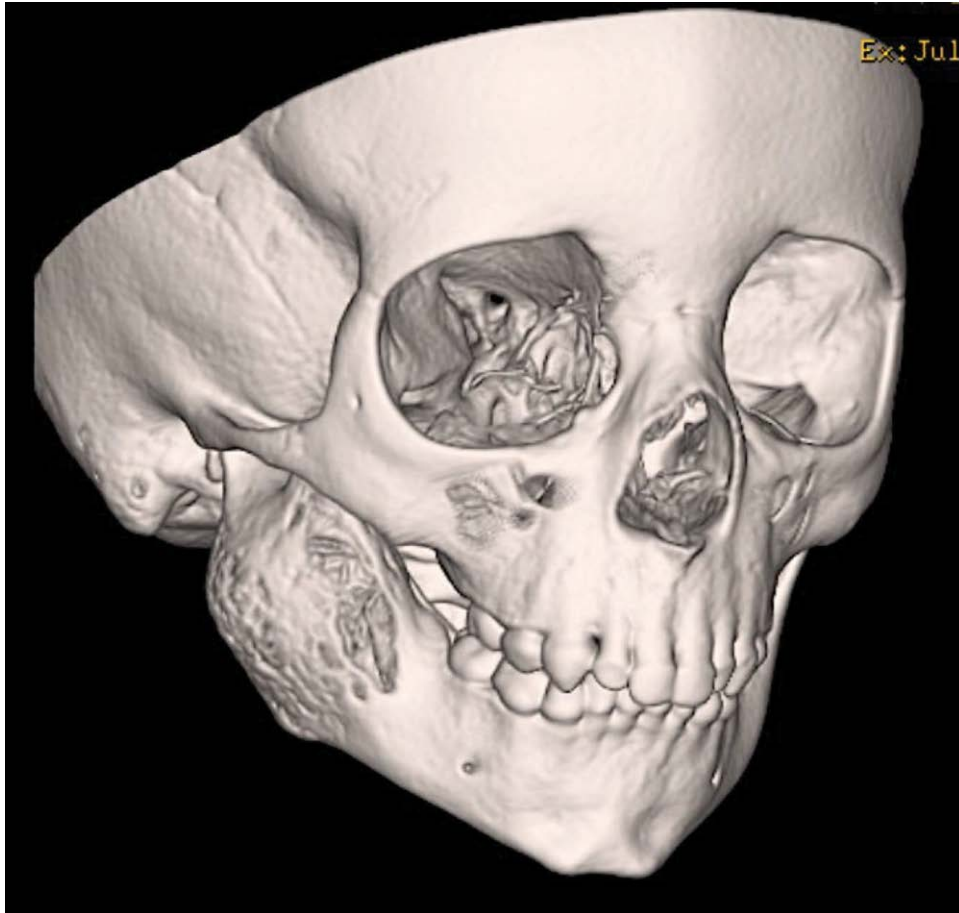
Preoperative crano-maxillofacial three-dimensional computed tomography reconstruction of the lesion.
